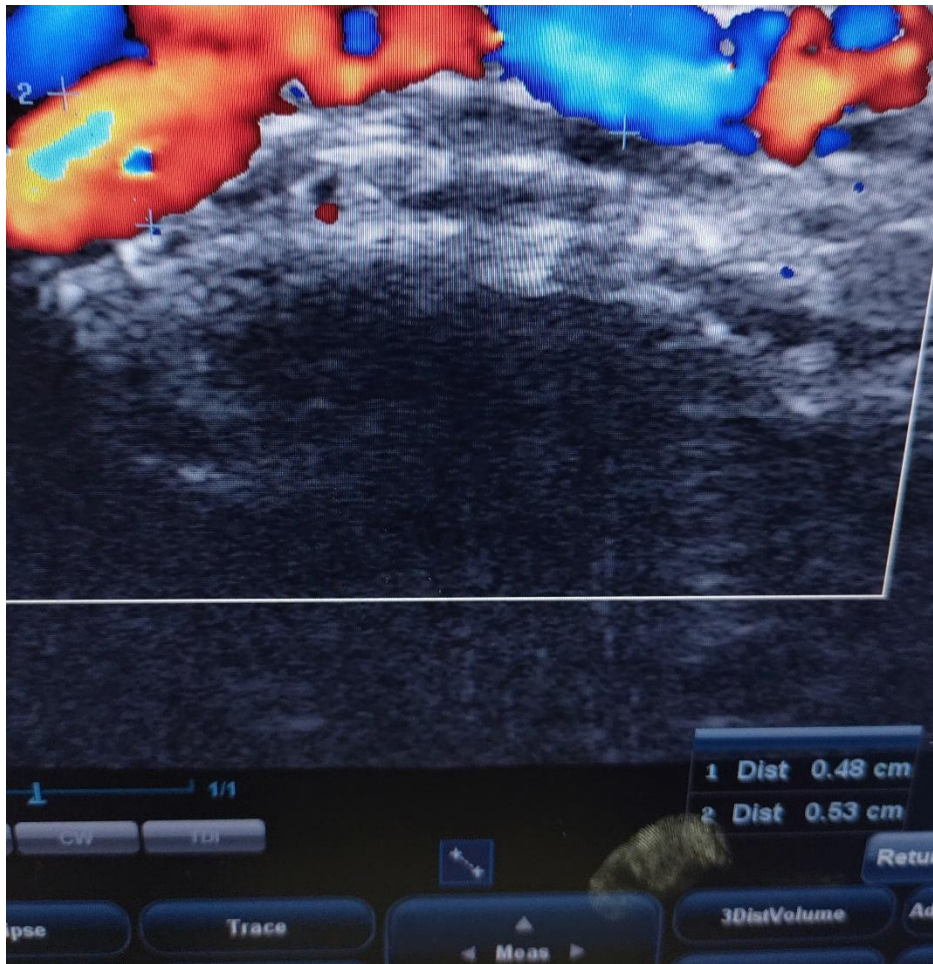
Scrotal Doppler Ultrasound scan revealing dilated pampiniform plexus of veins
